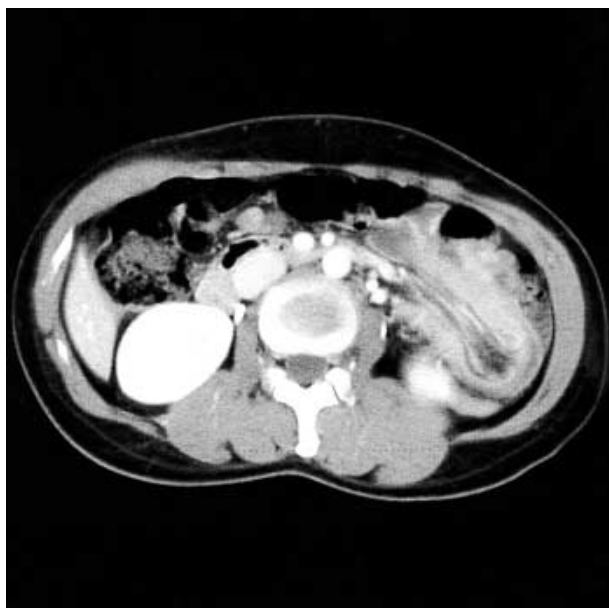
Abdominal computed tomographic scan reveals jejunal intussusception in the left abdomen with marked swelling of the wall.
